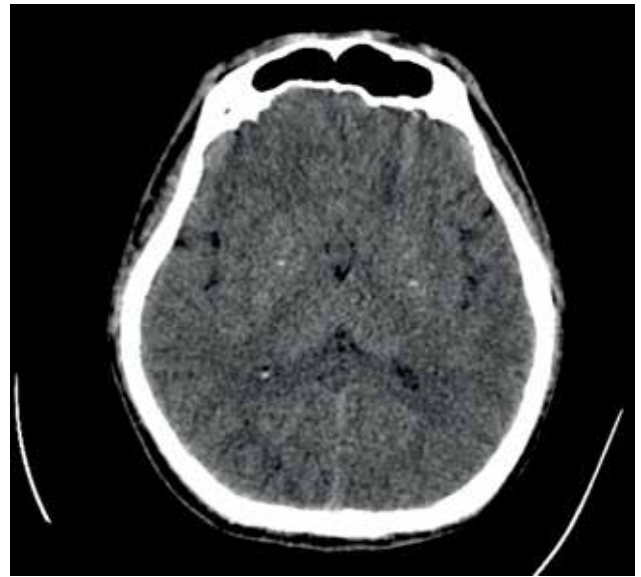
Non-contrast CT brain showed multiple hyperdense lesions around the basal ganglia. Neither infarction nor hemorrhage was found and other parts of the brain were within normal limits
